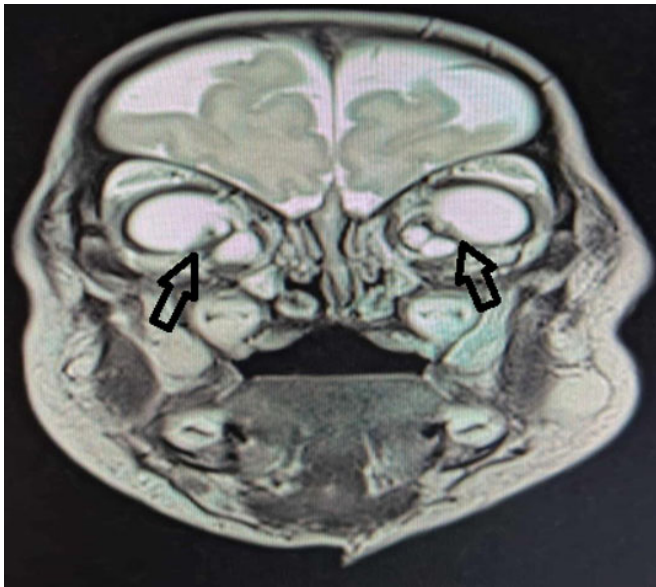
Coronal T2 MRI showing bilateral microphthalmia (black arrows), with small globes measuring approximately 11–12 mm in AP diameter.
